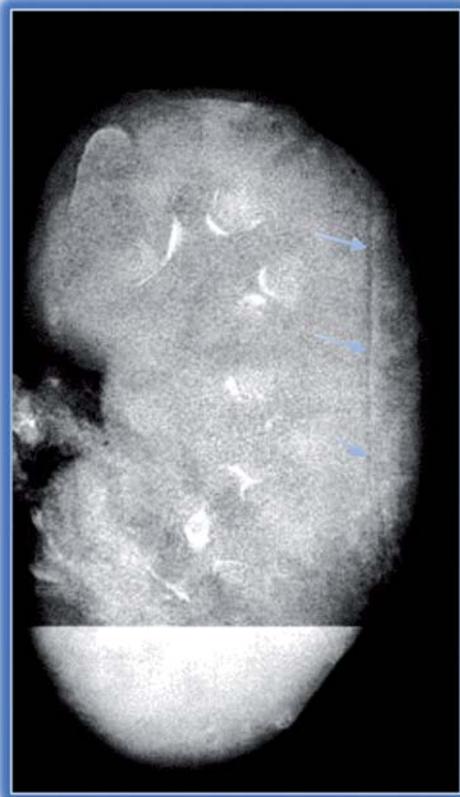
Radiography of the explanted kidney. The channel of the pO₂ catheter is marked by the three arrows.
